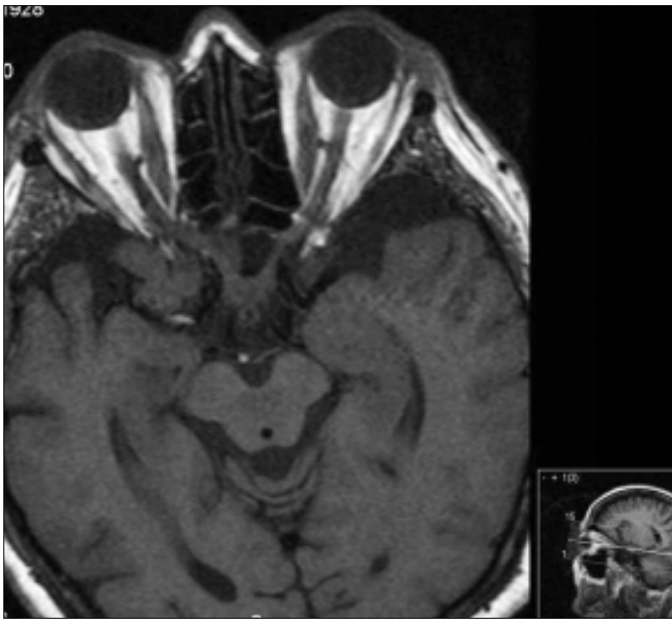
Magnetic resonance imaging of case-1 revealed Graves' ophthalmopathy
